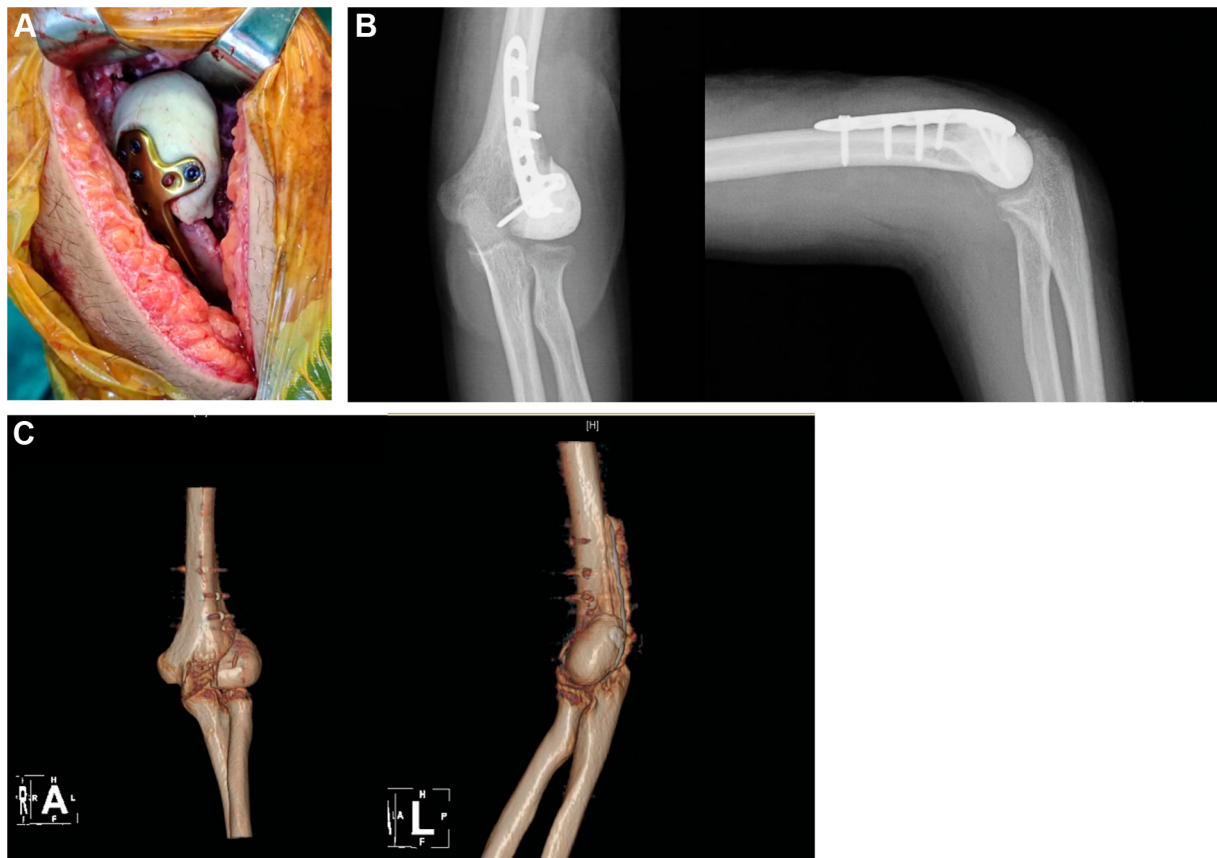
Intraoperative and postoperative images. (A) Image after placing the plate. (B, C) X-ray and 3-dimensional computed tomography after the surgery.
